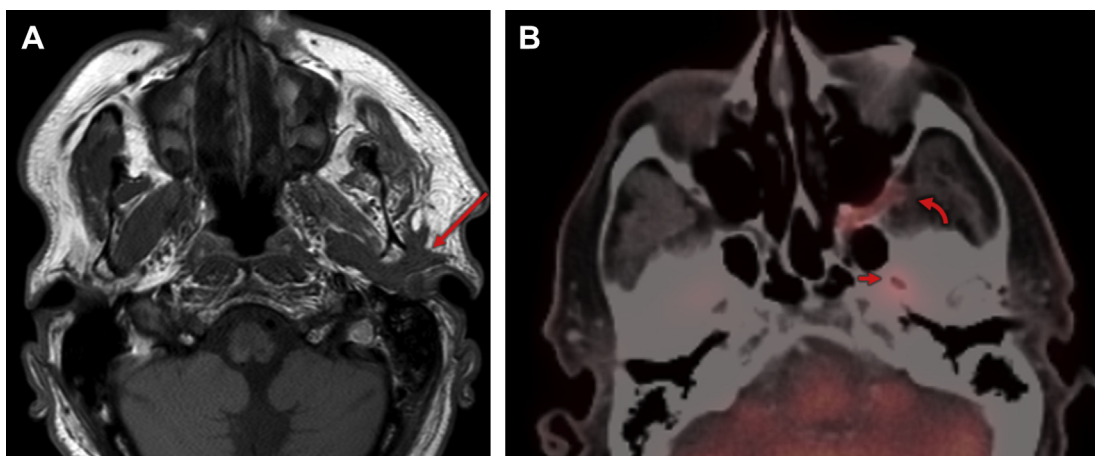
Parotid malignancies often have an impact on facial nerve function (note the left eyelid gold weight). The trigeminal nerve can also be affected via anastomotic connections. This T1 hypointense mass (*long arrow, A*) insinuates along the expected path of the auriculotemporal nerve (connecting CN V and CN VII). FDG PET-CT showed avidity in the left foramen ovale (*short arrow, B*), pterygopalatine fossa, and pterygomaxillary fissure (*curved arrow, B*). This 78-year-old man also had direct brain parenchymal invasion (not shown) and was initially described as an “atypical schwannoma.”
